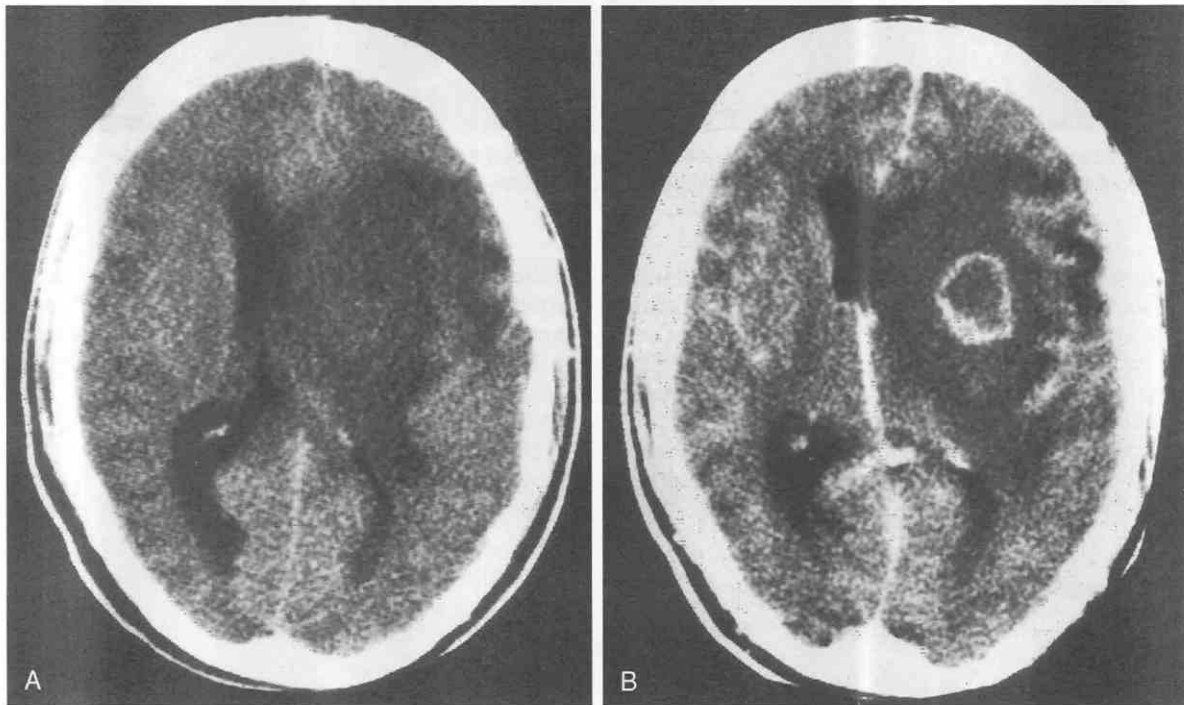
Toxoplasmosis. *A*, Noncontrast CT scan shows a large low-density area in the left frontoparietal region and left basal ganglion, with significant mass effect in a patient with acquired immunodeficiency syndrome. *B*, Contrast CT scan demonstrates a ringlike enhancing lesion.
